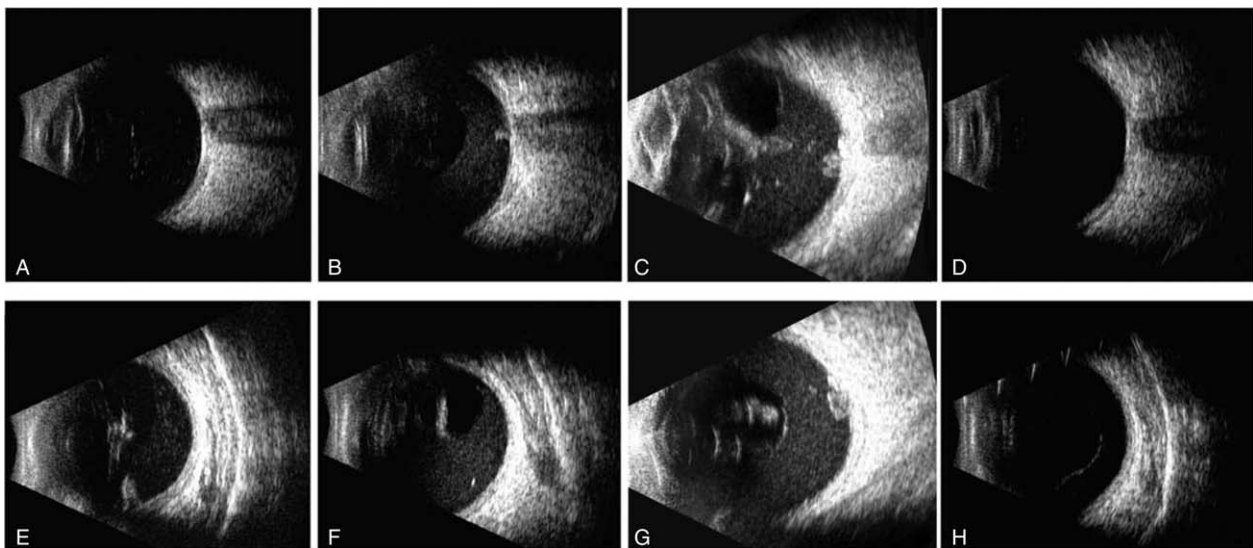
B ultrasonography images of the left eye at different time-points after surgery (A, E, at day 1 after phacoemulsification; B, F, at day 9 after phacoemulsification; C, G, at day 15 after phacoemulsification; D, H, at day 30 after vitrectomy). Upper panels (A, B, C, D) and lower panels (E, F, G, H) show the ultrasound images through the optic nerve and of anterior vitreous cavity, respectively.
